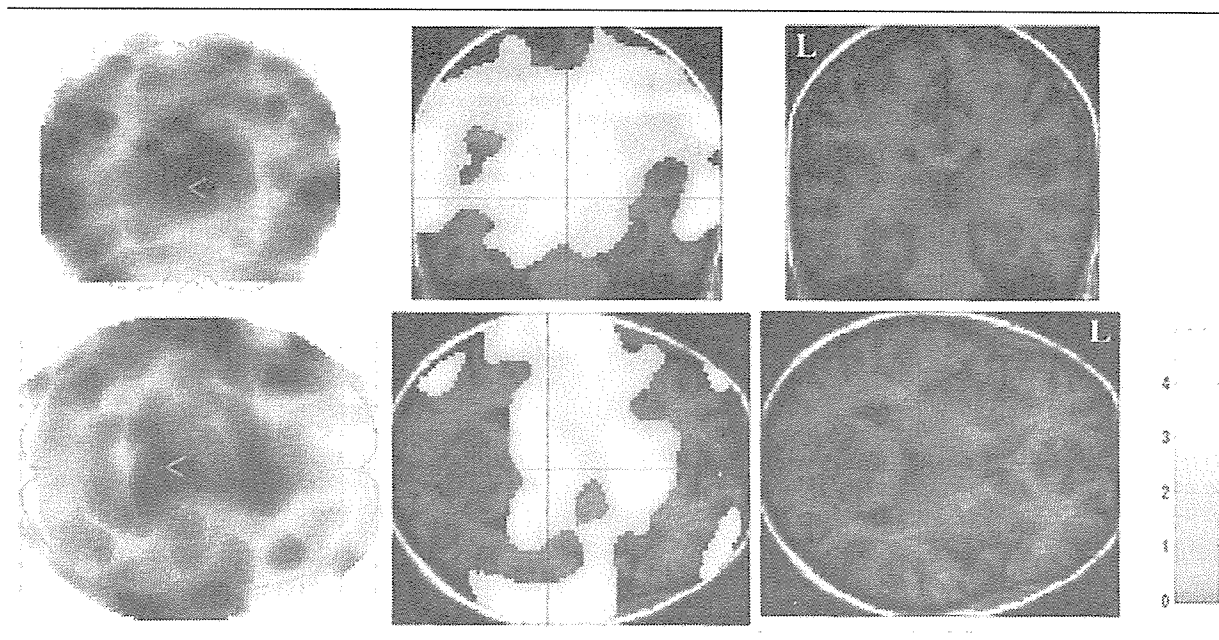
Brain areas with a significant decrease of [^{123}I]5-I-A-85380 distribution volume (V) in Parkinson's disease patients detected with a two-sample t test in Statistical Parametric Mapping version '02. Areas with a significant decrease are displayed in the glass brain (left) and on transverse and coronal slices through thalamus of a magnetic resonance (MR) image of a control subject (middle). Corresponding MR images without superimposition are shown on the right. Highlighted areas showed p less than 0.05 false-discovery rate, which was corrected for multiple comparisons. The area also showed cluster-level corrected p less than 0.001. Color bar shows T values with the maximum value of 4.96. Note that the glass brain view displays decreases in the entire brain superimposed to anteroposterior (top left) or top-bottom (bottom left) views, whereas the MR images with the superimposition display decreases on single slices.
